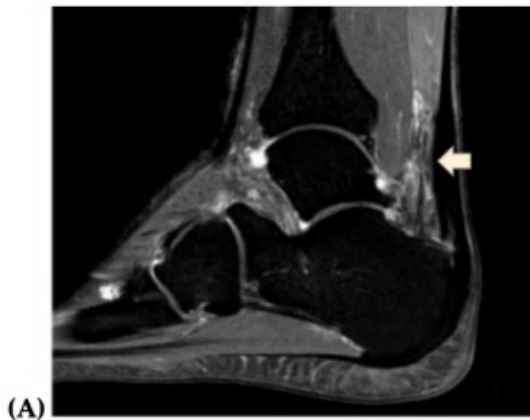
MRI images of a case presented by Gatz., et al. showed a partial rupture Achilles tendon (Kuwada's classification type I) (White arrow).¹⁶
